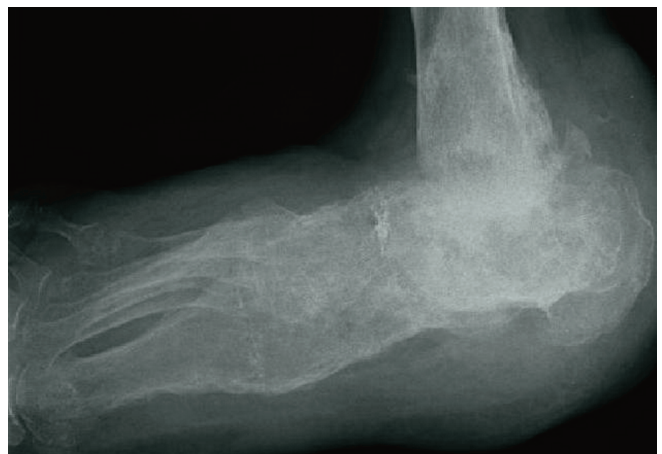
Preoperative radiograph demonstrating avascular necrosis of the talus with complete collapse of the bone and severe joint depression.
